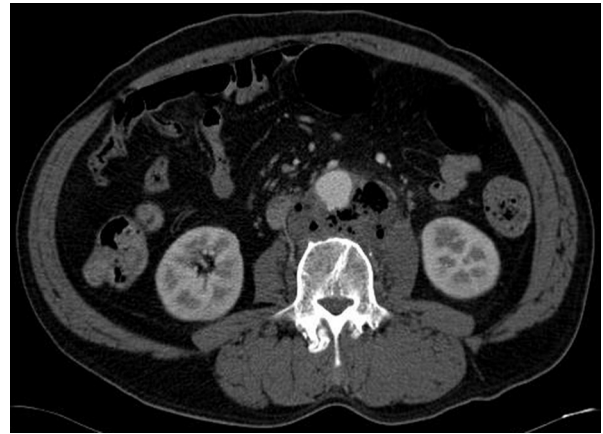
Computed tomography (CT) showed a 7-cm, gas-forming retroperitoneal abscess in the posterior aspect of the abdominal aorta at the level of the L3 vertebral body. A small outpouching lesion in the posterior wall of the abdominal aorta was observed, which ruptured during abscess drainage.
